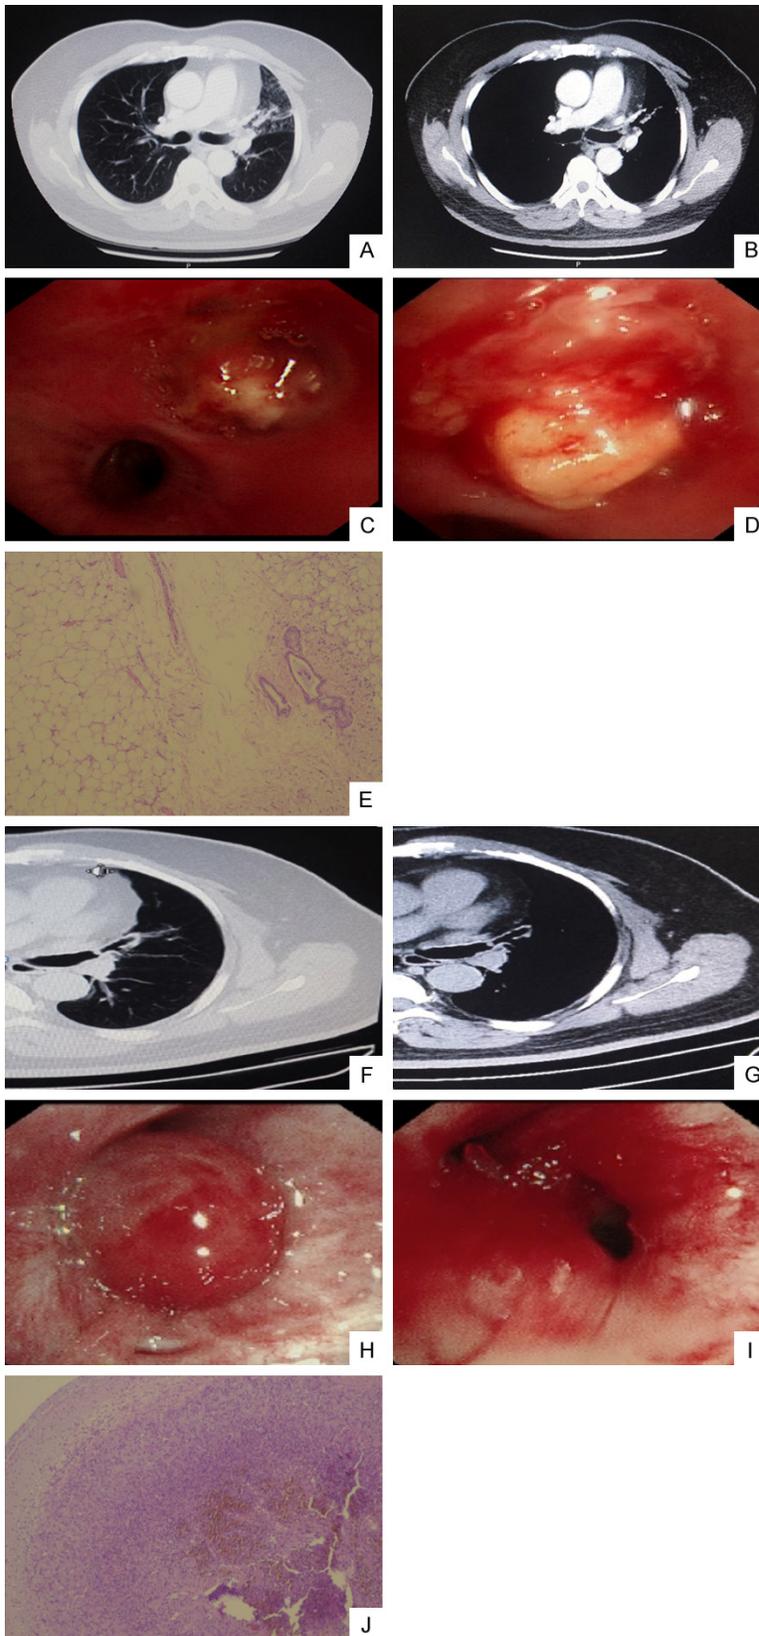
A. CT pulmonary window: as shown in the left upper lobe bronchial stenosis, distal obstructive atelectasis. B. CT mediastinum window: Fat density shadow is visible in the left upper lobe bronchus with CT value-100
